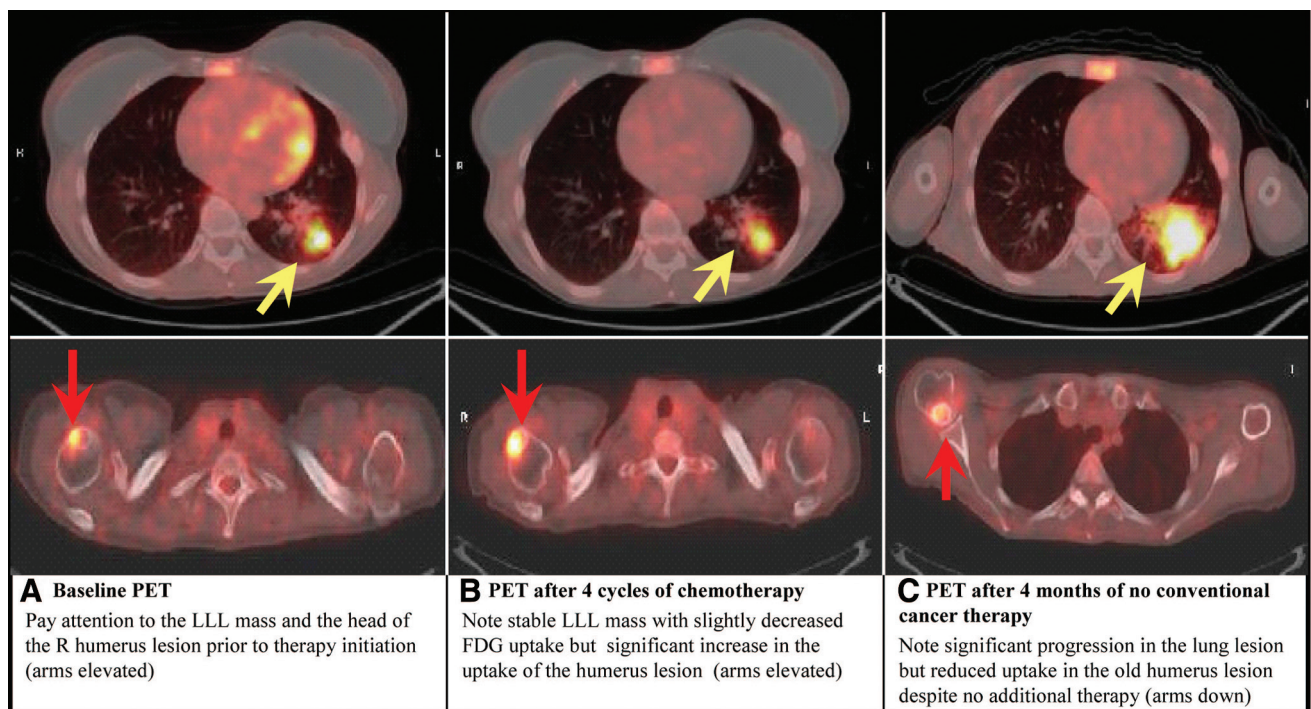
Patient #1, Fusion Image of changes in positron emission tomography/computed tomography (PET/CT) during therapy and after therapy cessation focusing on a lung lesion and a lesion in the right humerus. The arms are up on the first two scans and down on the last one, explaining the positional change of the humerus lesion.
